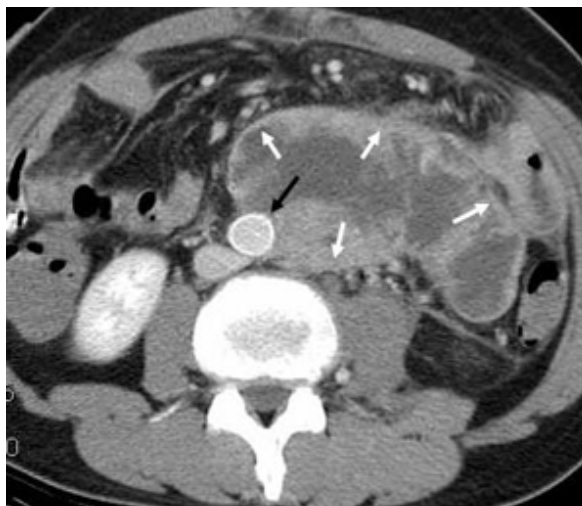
Post-op followup CT shows an interposed graft(black arrow) in the aortic lumen and huge soft tissue mass(white arrows) which is partially abutting to aortic wall.
